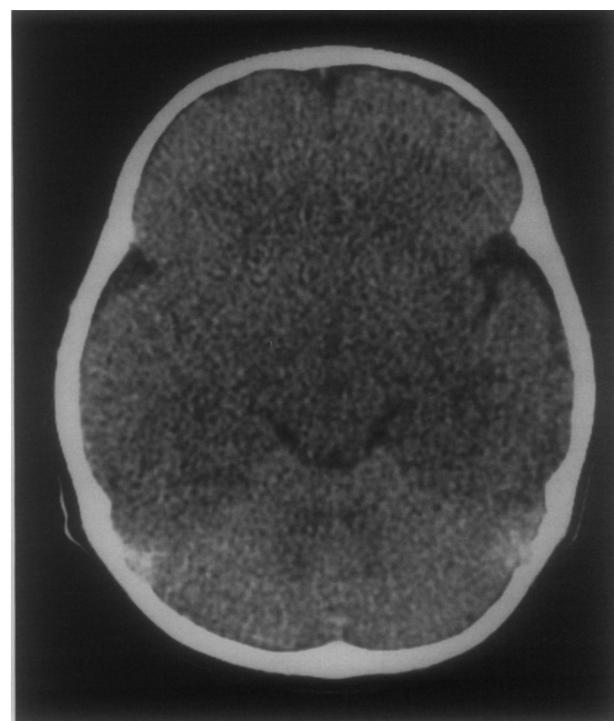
Axial non-enhanced CT through the brain in an abused child demonstrating an oedematous brain with generalized swelling and compression of the ventricles and sulci and a loss of grey-white matter differentiation.
